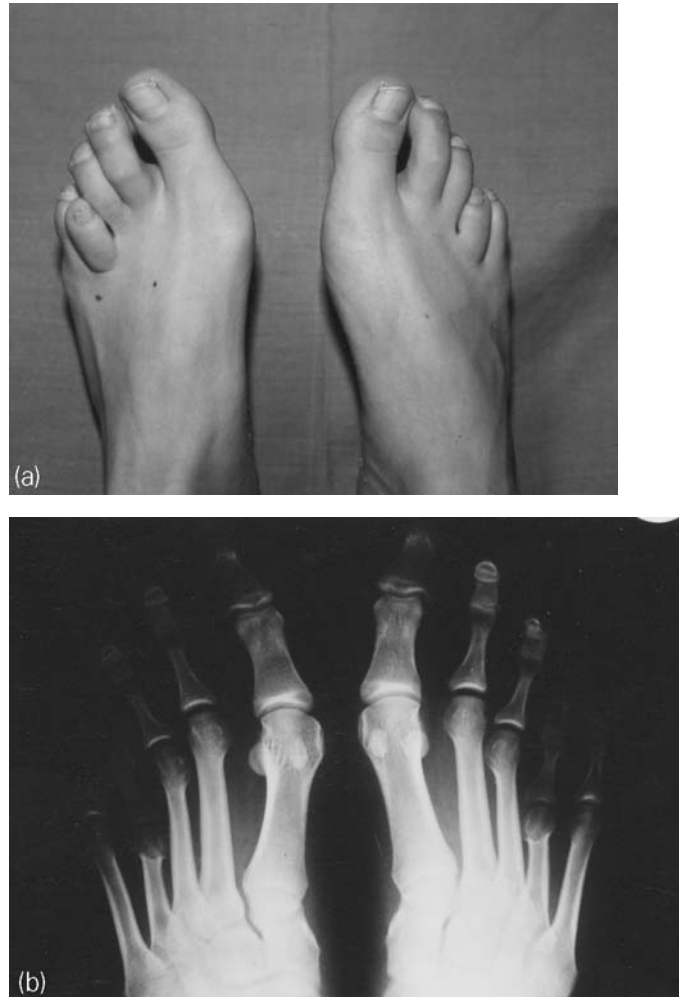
A 17-year-old girl with congenital bilateral shortening of the fourth metatarsal. (a) Clinical photograph before treatment, showing bilateral shortening of the fourth metatarsal. (b) Radiograph before treatment, showing bilateral shortening of the fourth metatarsal. (c) Radiograph taken during lengthening of the fourth metatarsal on the right foot with the apparatus in situ. (d) Radiograph of the result of the lengthening on the right foot 2 months after removal of the apparatus. (e) Radiograph showing the bilateral result of lengthening. (f) Clinical photograph showing the bilateral result of lengthening.
